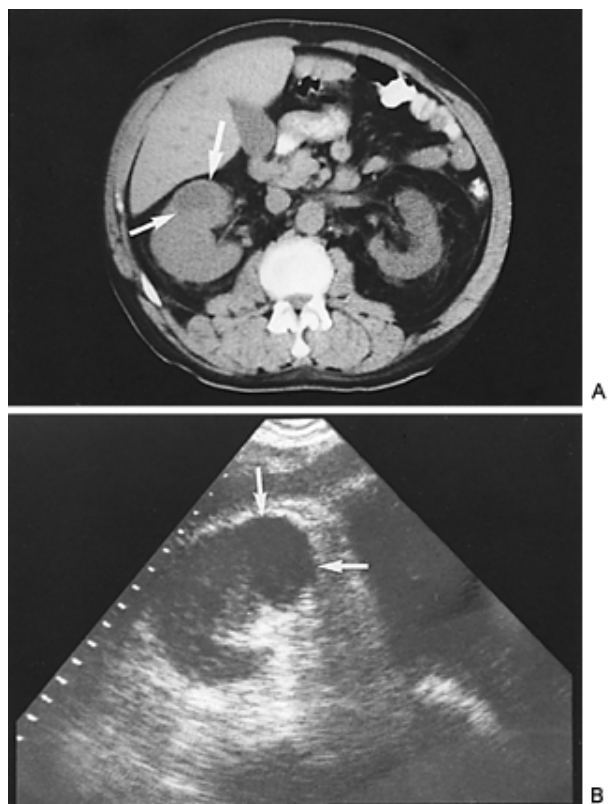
Acute renal abscess. A: Nonenhanced computed tomography scan through the midpole of the right kidney demonstrates right renal enlargement and an area of decreased attenuation (*arrows*). After antimicrobial therapy, follow-up scan showed complete regression of these findings. B: Ultrasound. Transverse scan of the right kidney demonstrates a poorly marginated rounded focal hypoechoic mass (*arrows*) in the anterior portion of the kidney.
